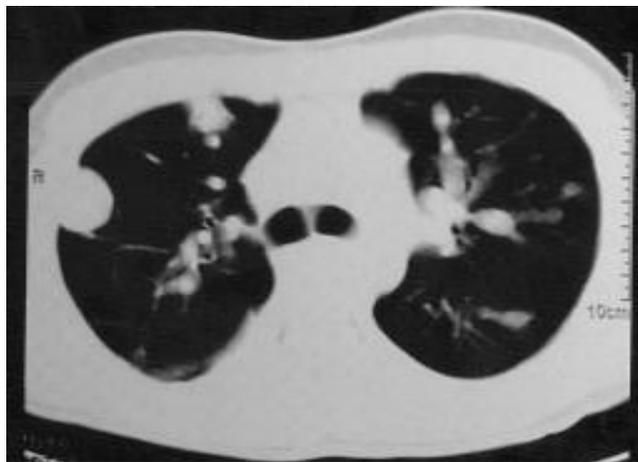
Transverse thin section CT scan obtained at the level of carina again shows well defined, subpleural, rounded, pulmonary parenchymal density in the right middle lobe.
